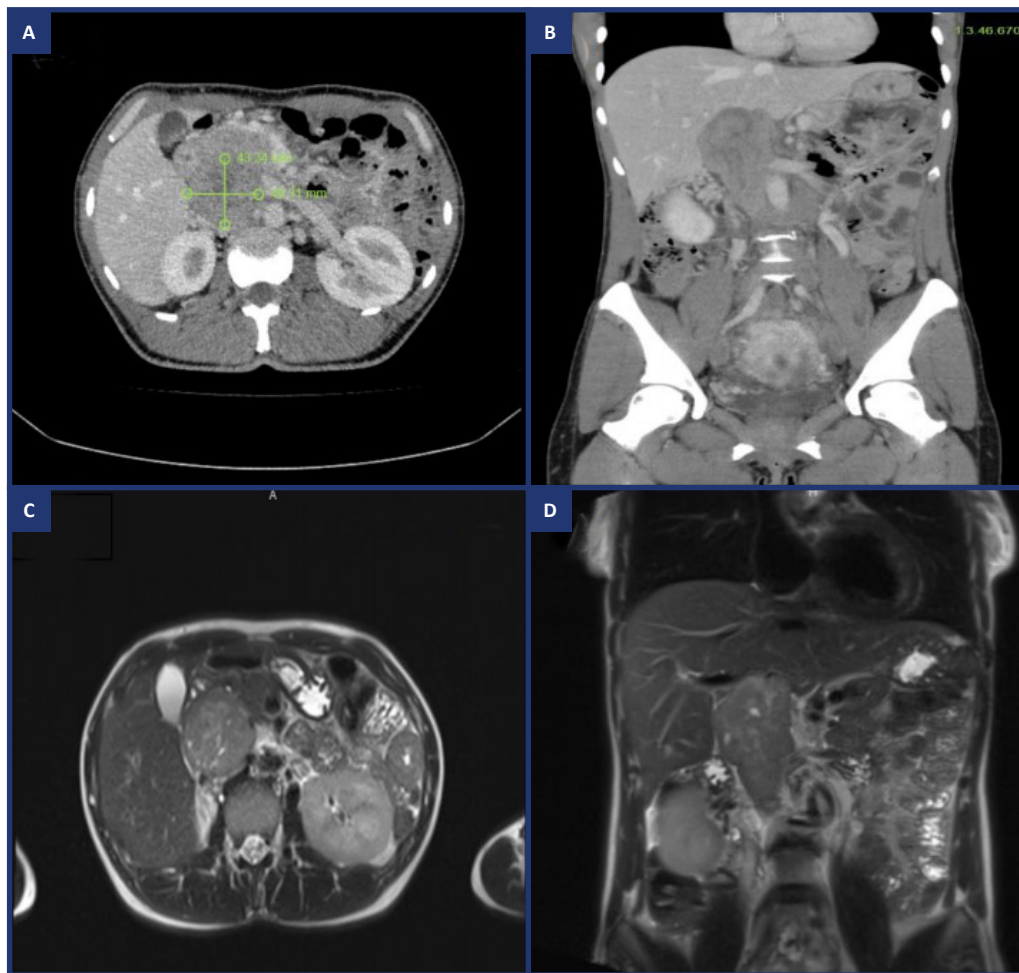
A and B. Computed tomography with intravenous contrast. A. Axial slide. B. Coronal slide. C and D. Magnetic resonance cholangiopancreatography. C. Axial slide. D. Coronal slide.
